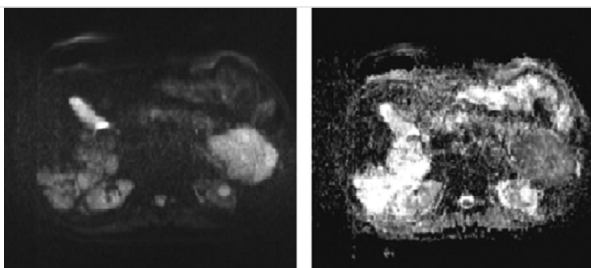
Abdominol MR image 1
